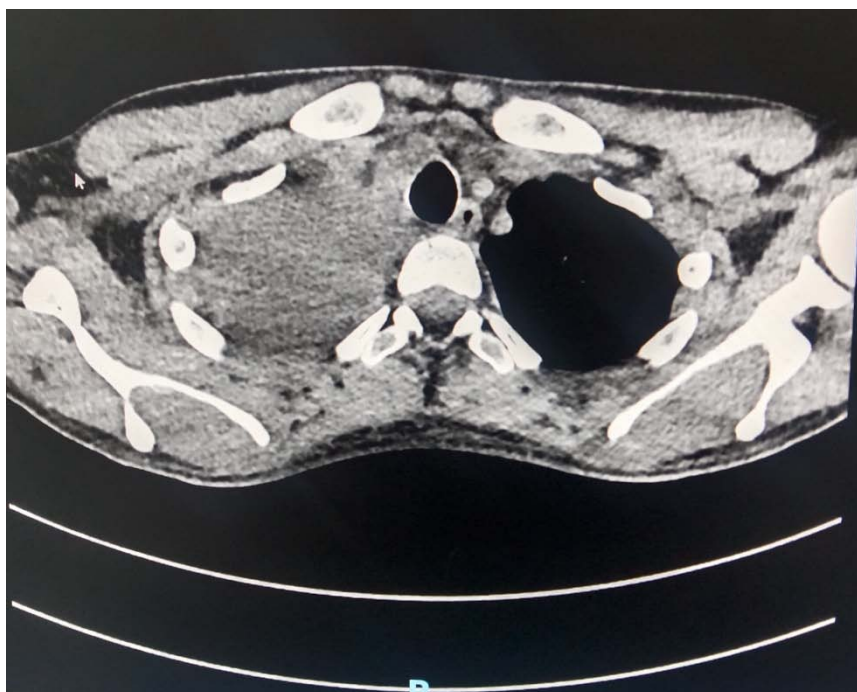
CT Scan showing the massive Hemothorax
